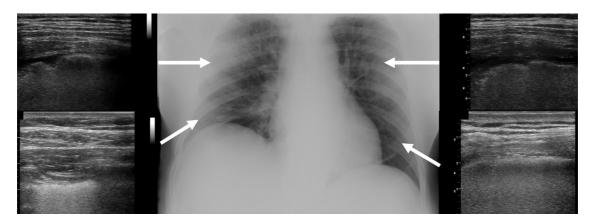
Chest X-ray on admission shows diffuse interstitial abnormalities alongside scattered bilateral infiltrates. Arrows indicate the local ultrasound patterns, in particular: irregular vertical artifacts (B-lines) with impaired pleural sliding next to subpleural small consolidations in the upper anterior sites and thick and confluent B lines in the low posterior site.
